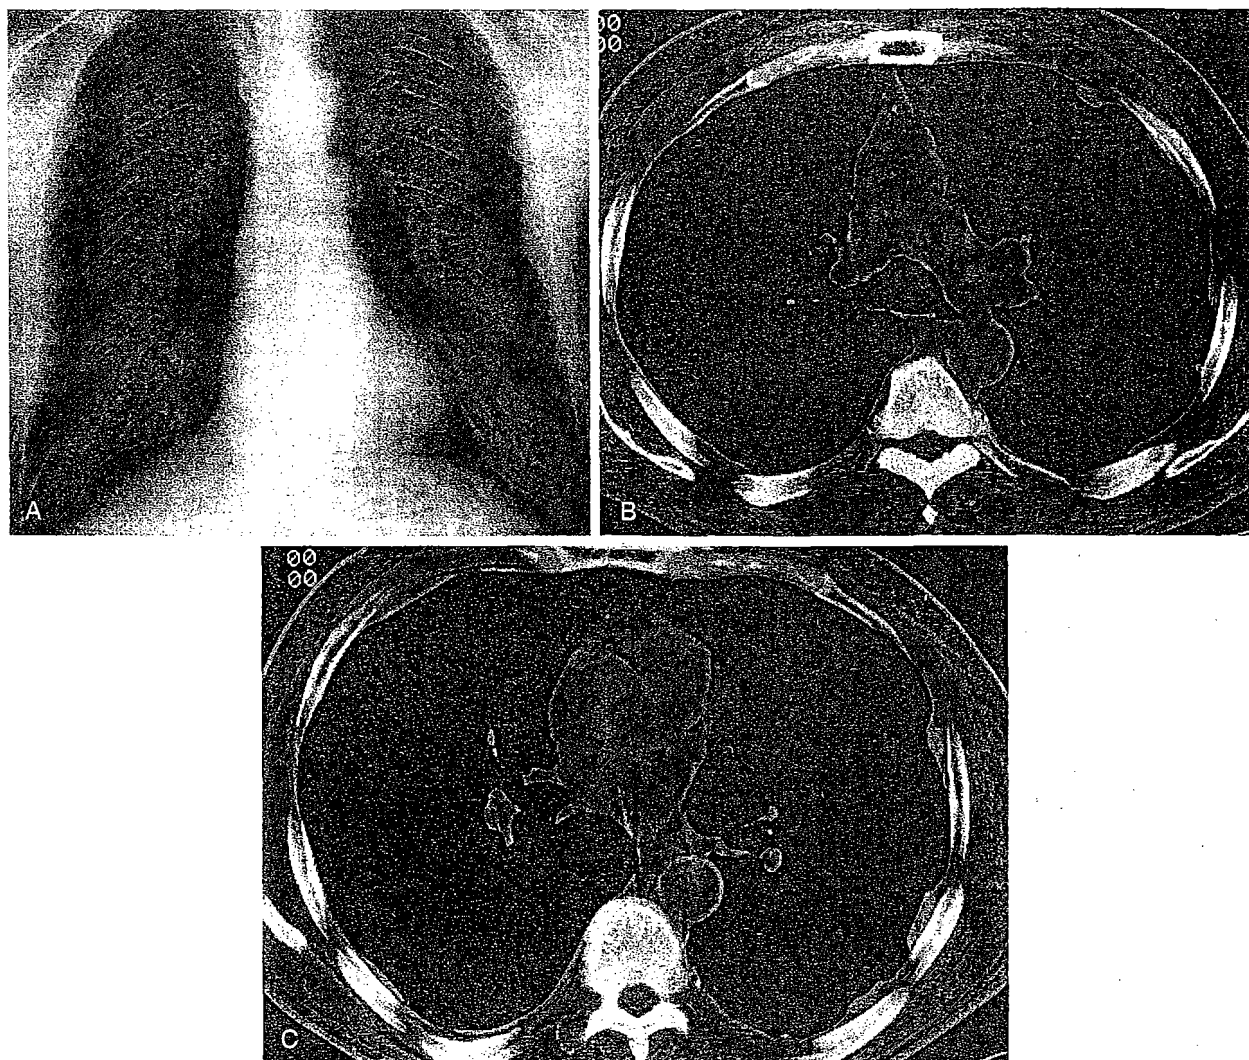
Markedly Asymmetric Pleural Plaques. A posteroanterior chest radiograph (A) in a 74-year-old shipyard worker shows evidence of pleural plaques only on the left side. HRCT at the level of the tracheal carina (B) also demonstrates only plaques on the left side. HRCT through the lower lung zones demonstrates prominent plaques on the left and thin plaques on the right.
